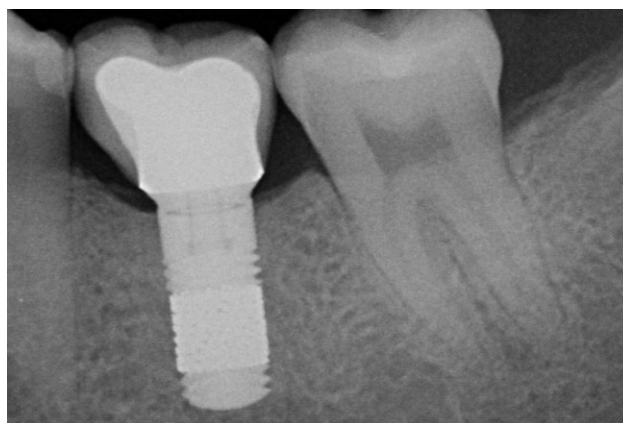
Postoperative (1 year): radiograph shows stable crestal bone levels.
